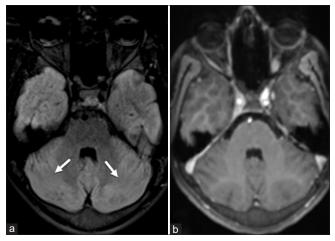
Subtle FLAIR hyperintensity of bilateral cerebellar folias suggestive of cerebellitis (pointed by arrows in image) (a). T2 FLAIR; (b). T1 post contrast MRI Brain
